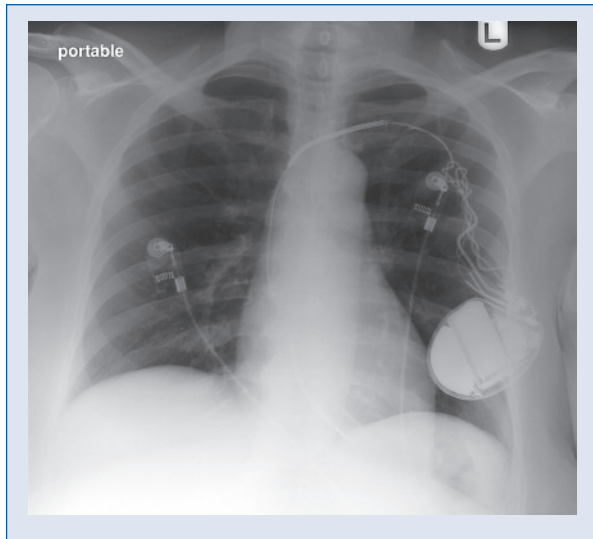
Preoperative chest X-ray showing severe twisting of the ICD lead as well as non-existent slack.
